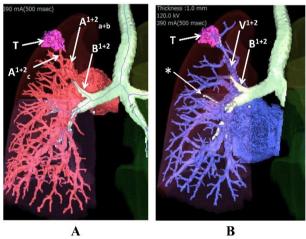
Multiplanar reconstruction CT image using a 3-dimensional volume analyzer.
